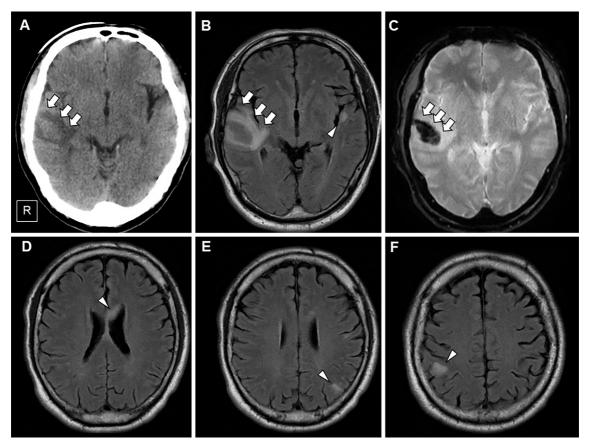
Brain computed tomography (A) and magnetic resonance imaging (B-F) on admission. Brain CT revealed a mass lesion in the right temporal lobe, exhibiting a slightly higher-density area inside the lesion (A, arrows). The lesion demonstrated isointensity within the lesion and high intensity in the surrounding region [fluid-attenuated inversion recovery (FLAIR)] (B, arrows), along with low intensities on T2 star-weighted imaging (C, arrows). In addition, high-intensity FLAIR lesions were observed in the genu of the corpus callosum (D, arrowhead), white matter of the left temporal lobe (B, arrowhead), and parietal lobes bilaterally (E, F, arrowheads).
